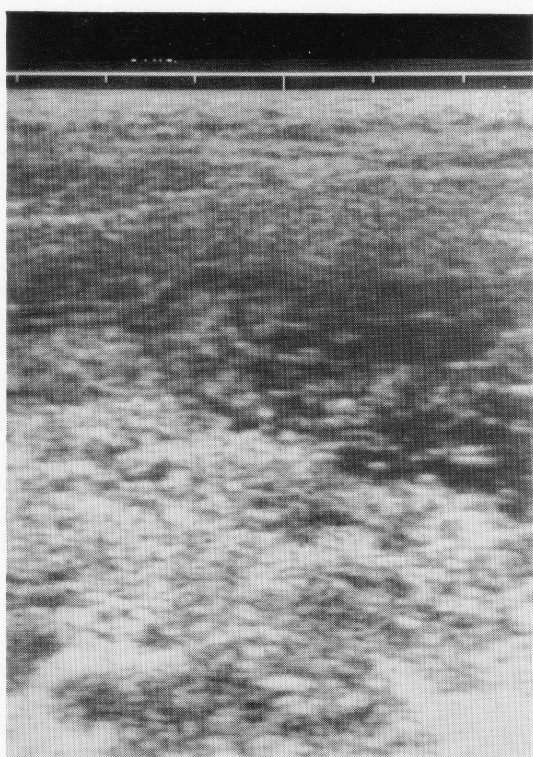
Transverse sonogram of lower abdomen. Many small anechoic areas in a large echogenic mass.
